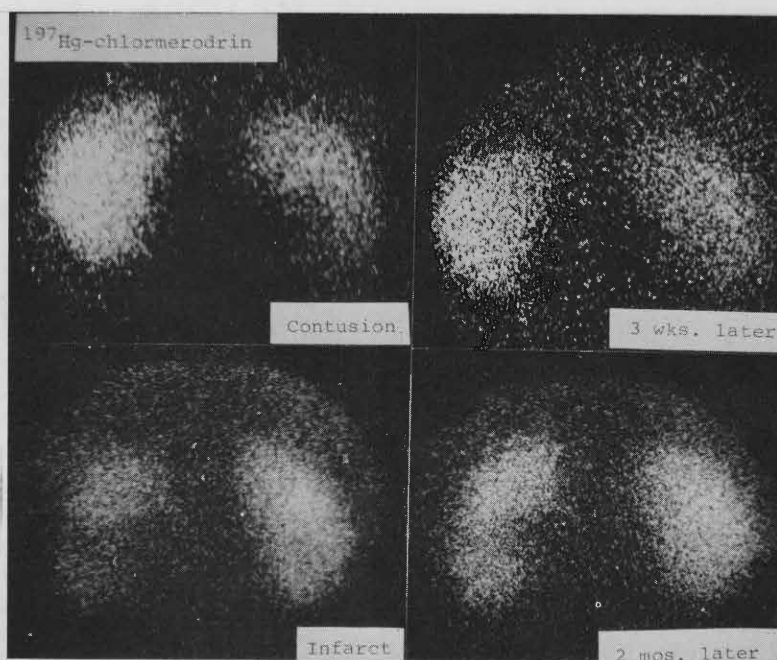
Value of serial radionuclide examination in differentiating between renal contusion and infarction. Posterior  $^{197}\text{Hg}$ -chlormerodrin scintigraphy following blunt trauma (*top row*) shows diminished activity in the medial portion and lower half of the right kidney. Repeat study 3 weeks later demonstrates considerable improvement in the appearance of this contused kidney. Sequential radiochlormerodrin study in another patient with blunt trauma (*bottom row*) shows a band of decreased activity through the midportion of the left kidney, which remains relatively unchanged after 2 months. Subsequent studies showed no change over 4 additional months. An area of contused parenchyma seen below the infarct shows marked improvement on the 2-month study. This patient is being followed closely for the possible development of hypertension.
